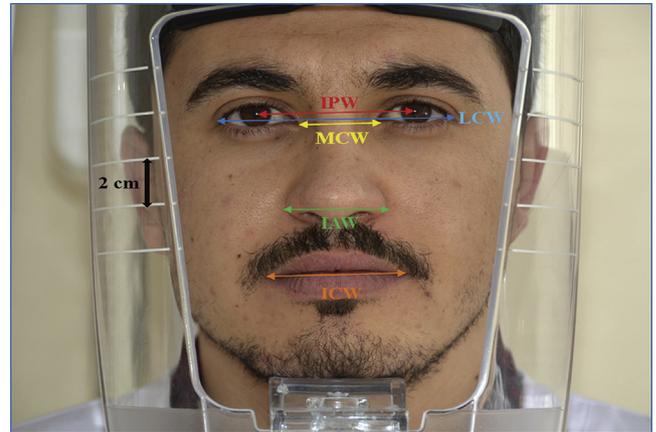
Immobilization of participant's head for photography using radiograph device. IAW, interalar width; ICW, intercommissural width; IPW, interpupillary width; LCW, interlateral canthus width; MCW, intermedial canthus width.
